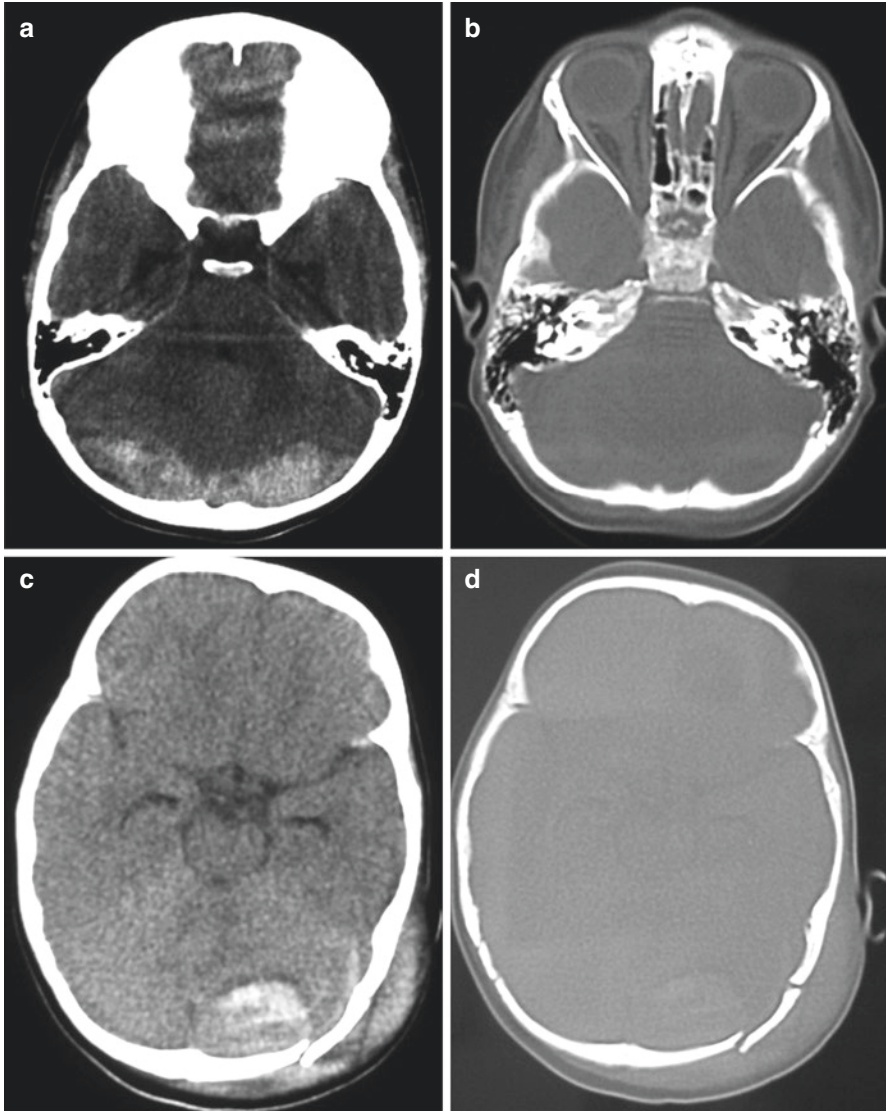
(a) An 8-year old boy was admitted after a fall from 2 m height with headache and vomiting. The GCS score was 14. CT revealed a posterior fossa EDH with (b) a concomitant occipital fracture. The hematoma was evacuated via a midline suboccipital craniotomy. (c and d) A 10-year old boy presented in the emergency department after a bicycle accident. The GCS score was 12. On physical examination there was a large left occipital subgaleal hematoma in the left side. CT scan revealed an occipital bone fracture with a concomitant EDH
